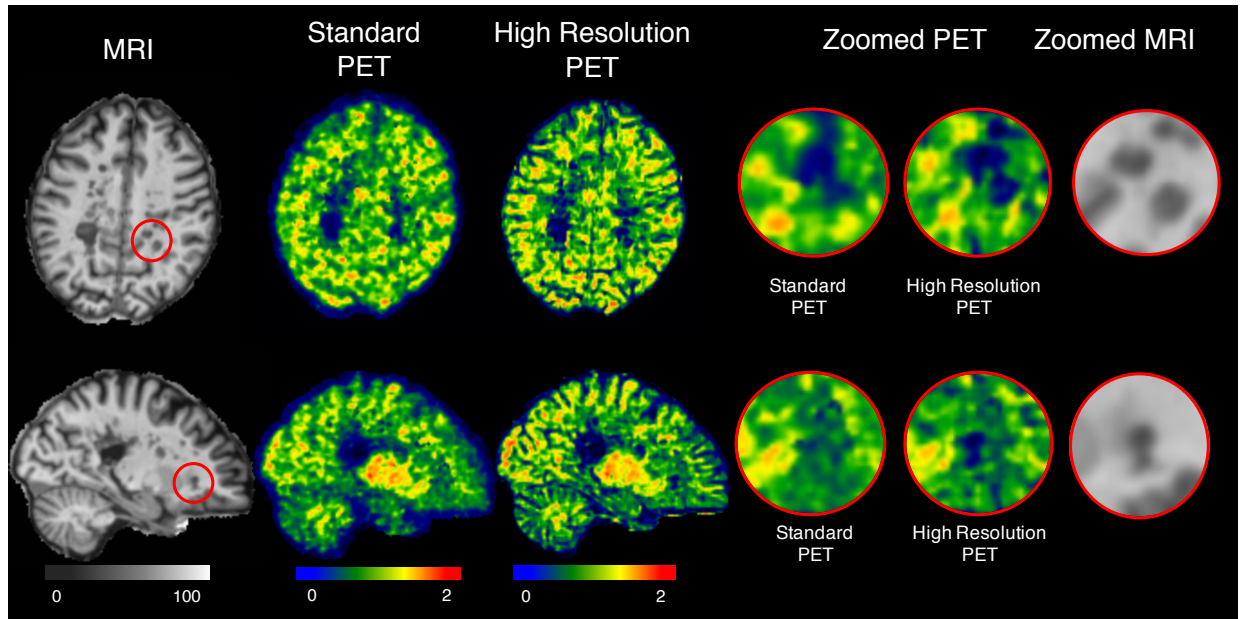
Axial and sagittal views from a representative MS patient. From left to right: MRI images; Standard PET; High Resolution PET; zooms of the area delimited in the MRI image with a red circle.
